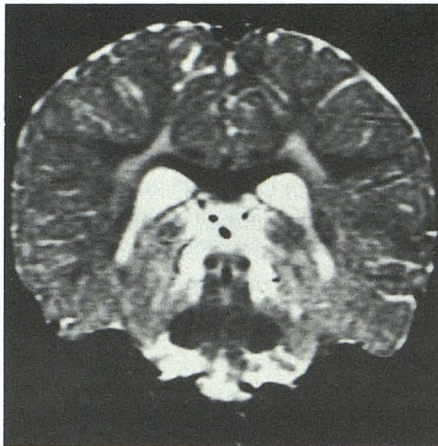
MR image 3500/16 shows patchy periventricular high signal in white matter of parietal lobes in 12-month-old boy with biopsy-proved Alexander disease. CT scan (not shown) was normal.
